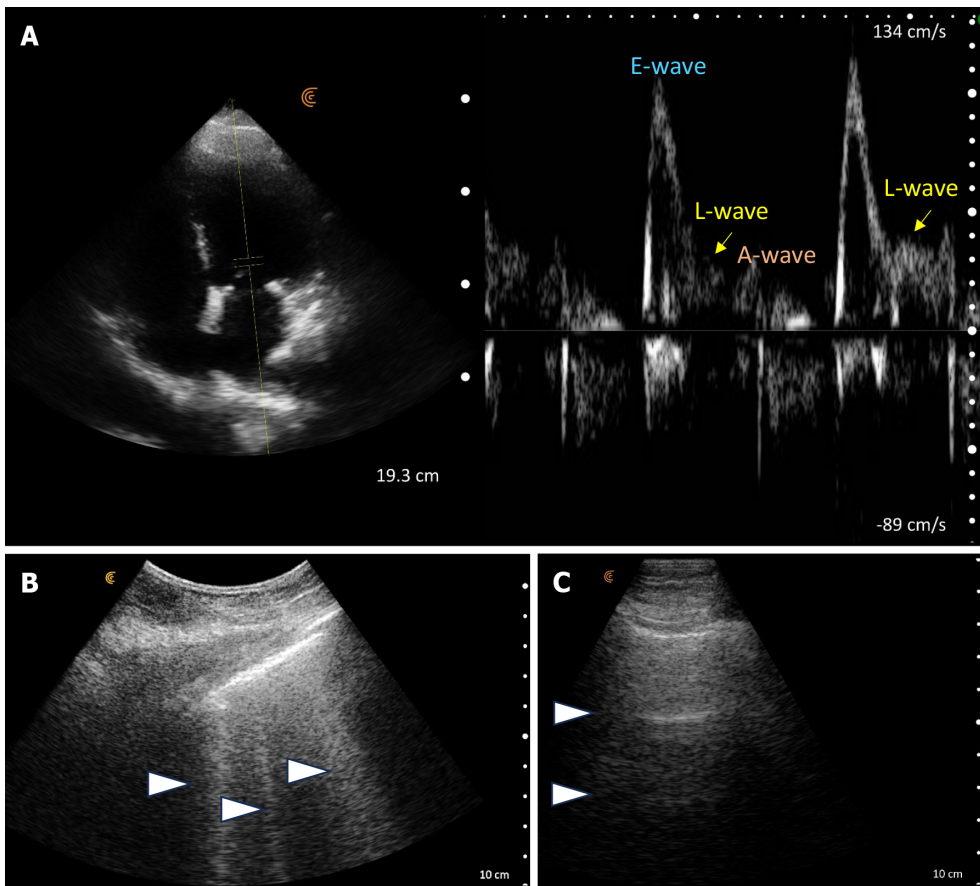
Point-of-care ultrasound images at the time of nephrology consult. A: An elevated E-wave to A-wave ratio and an L-wave on transmitral Doppler; B: Vertical B-lines on lung ultrasound at initial examination (arrowheads). Follow up lung ultrasound; C: Horizontal A-lines (arrowheads) on lung ultrasound - normal finding.
